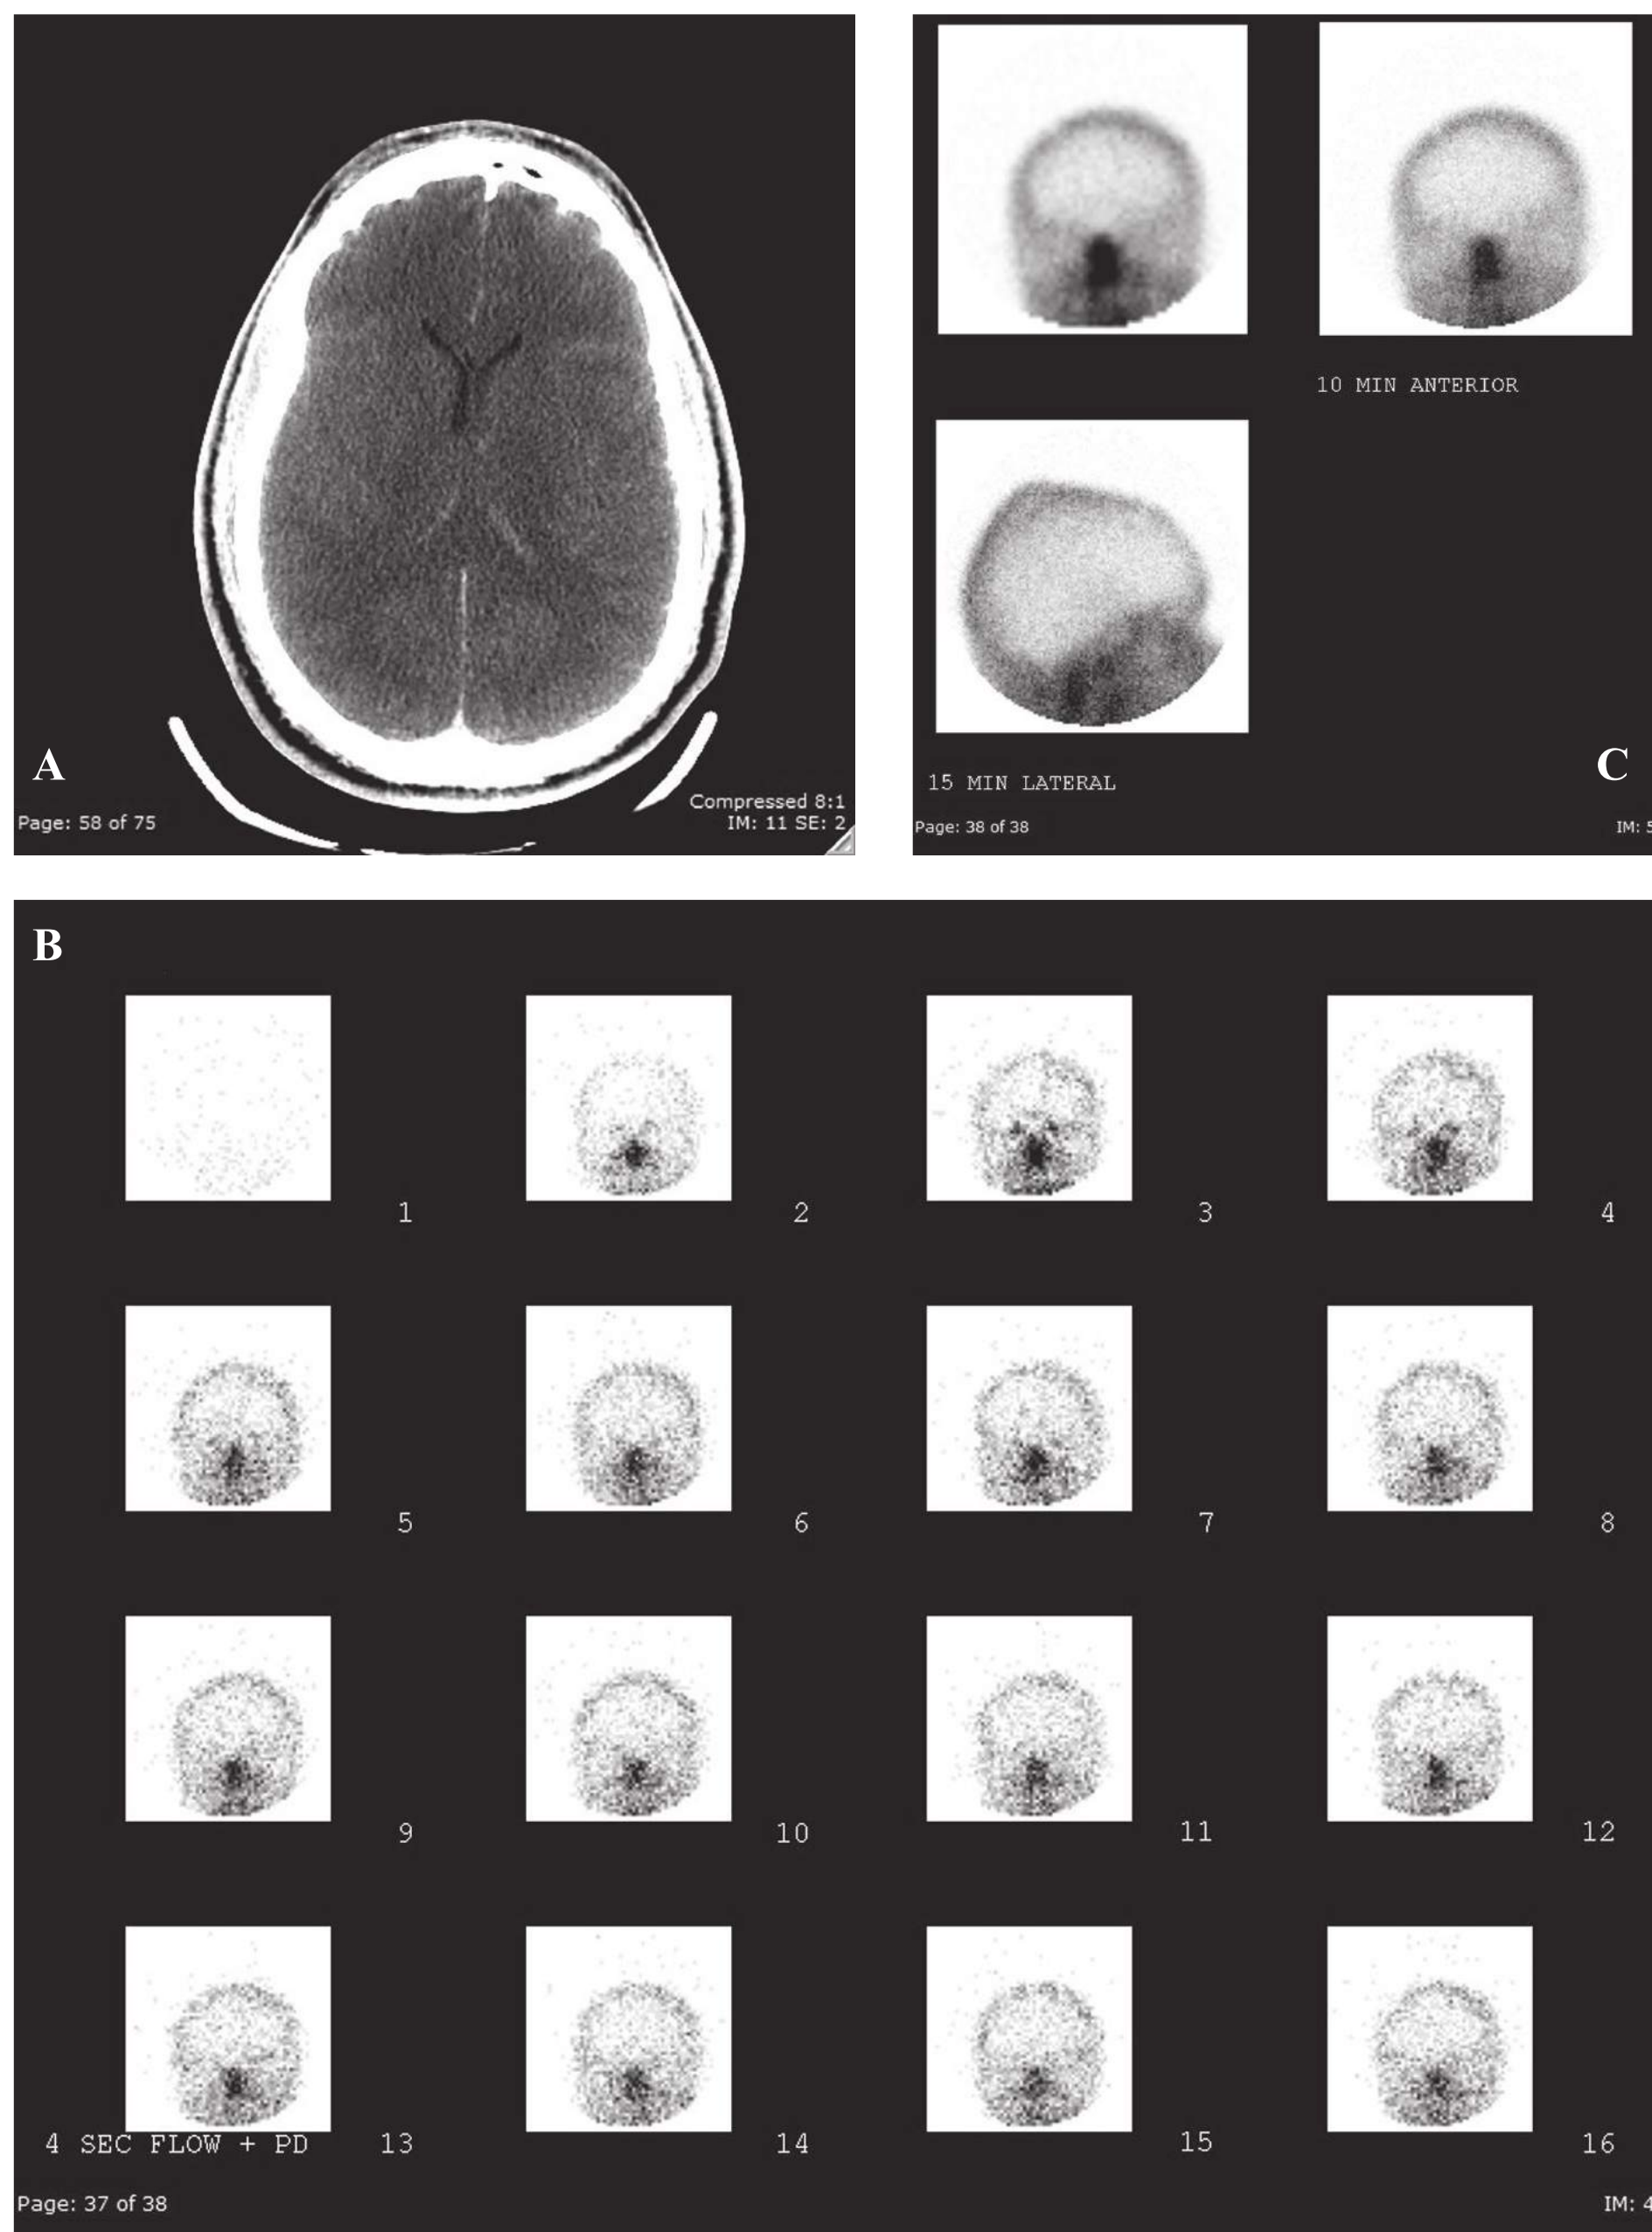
(A-C) CT head and radionuclide brain flow scan. The patient presented post-motor vehicle collision. The CT imaging demonstrates diffuse subarachnoid hemorrhage, acute intraventricular hemorrhage in the occipital horns, and reduction in gray-white matter differentiation with reduction in lateral ventricle size raising suspicion for increased cerebral edema. Progression in clinical exam was consistent with brain death. Radionuclide Tc-99m HMPAO was administered intravenously and anterior blood (vascular) flow images of the head and neck were obtained followed by a static image of the brain. Gamma camera imaging demonstrates no intracranial blood flow. There is no anterior and middle cerebral arterial blood flow, along with no activity in the cerebral hemispheres, the cerebellar hemispheres, and the brainstem. “Hot nose sign” is present with diversion of blood flow to the external carotid circulation.
